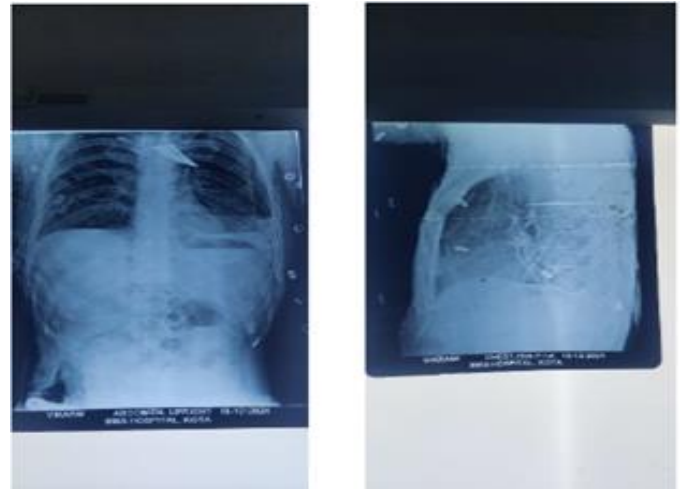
Chest radiograph 1. frontal and 2. lateral view showing white opacity in left anterior chest wall.
